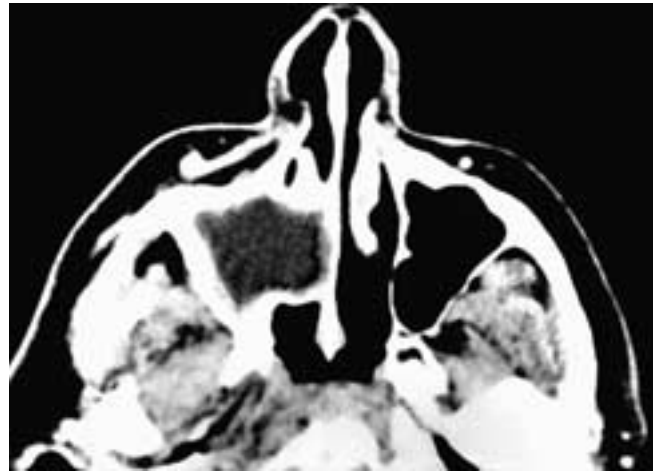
Axial contrast-enhanced CT scan shows an expansile right maxillary sinus mucoid attenuation mass that has a thin enhancing rim. This patient had a right maxillary sinus mucopyocoele.
